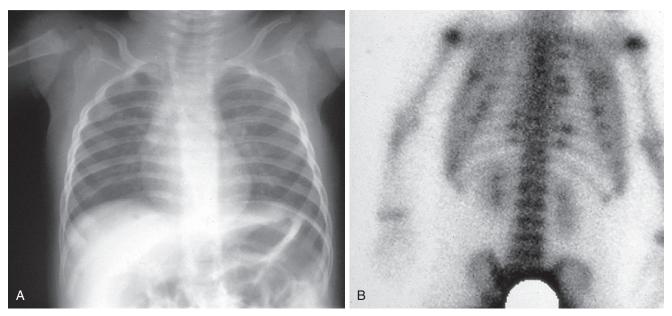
Use of bone scan to detect occult rib fractures. A, At 3 months of age, this infant presented with low-grade fever, nasal congestion, cough, tachypnea, and intermittent grunting respirations. Pneumonia was suspected, and a chest radiograph was obtained. On review of the films, a subtle, nearly completely remodeled fracture of the posterolateral aspect of the right third rib was detected. In addition to his tachypnea, he was noted to cry when picked up by the chest. B, Bone scan revealed occult posterior fractures of the second through fifth ribs on the left and the eighth and ninth ribs bilaterally, as well as the one fracture seen on the chest film. The occult fractures became visible radiographically over the ensuing 2 weeks.
